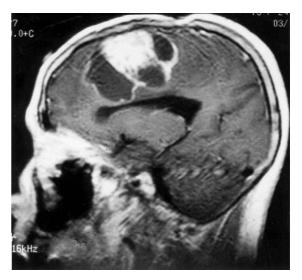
Sagittal MRI performed 8 years after surgery shows marked enlargement of mass. Note the lesion now has a multiloculated, cystic appearance combined with a solid, enhancing component.
